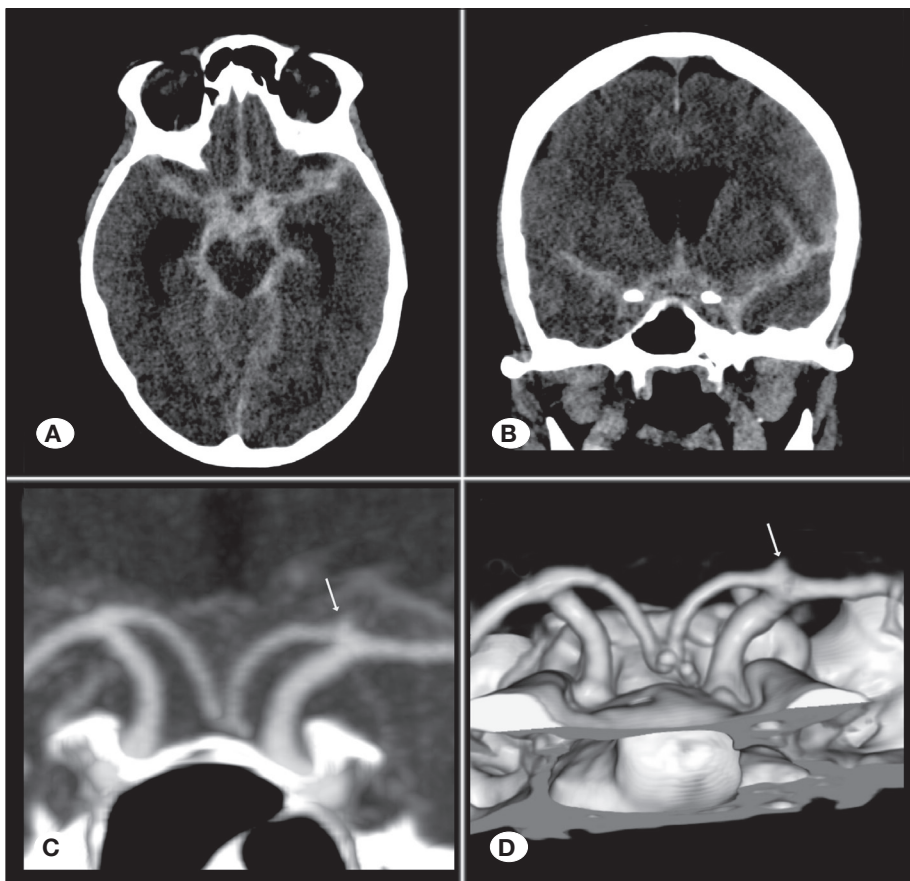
Initial non-enhanced CT, axial (A), and coronal (B) views, showing the presence of a diffuse subarachnoid hemorrhage in the basal cisterns and bilateral Sylvian fissures, Fisher scale III. A subsequent CT angiogram, MIP view (C), and 3D VR (D), showing a tiny and irregular ruptured A1 aneurysm (white arrows).
